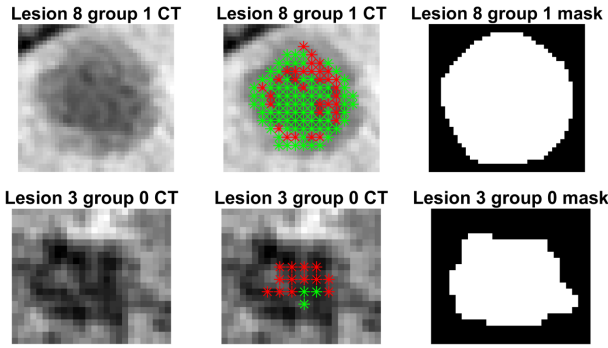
Examples of the classification of one slice of two different metastases: one R+ (first row) and 1 R- (second row). The first column represents the CT image, the second column shows the classification of each ROIs: in green are ROIs classified as R+ and in red ROIs classified as R- (only the center of each ROI is represented). The third column represents the manual mask used as reference standard.
